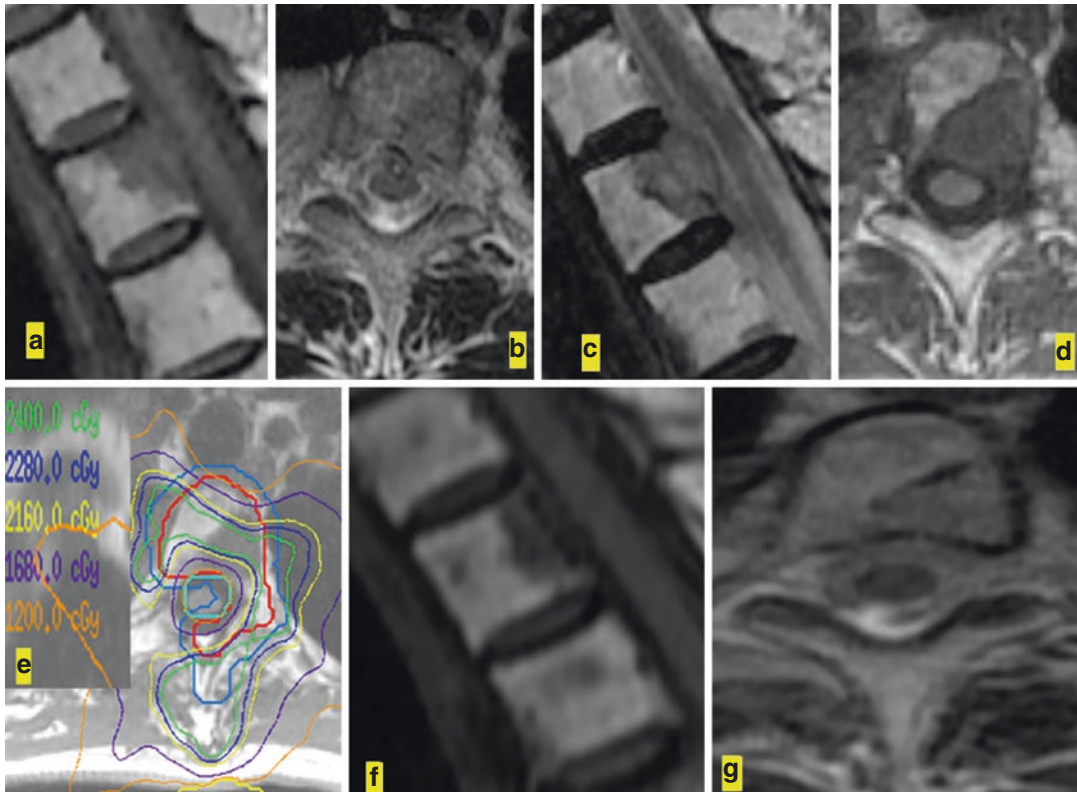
A patient with RCC found to have a metastasis in the left T2 vertebral body. (a) Sagittal T1 MRI, (b) axial T2 MRI prior to upfront SBRT. One year later there was progression with new left anterolateral epidural disease as seen in the (c) sagittal T2 MRI and (d) axial T1
